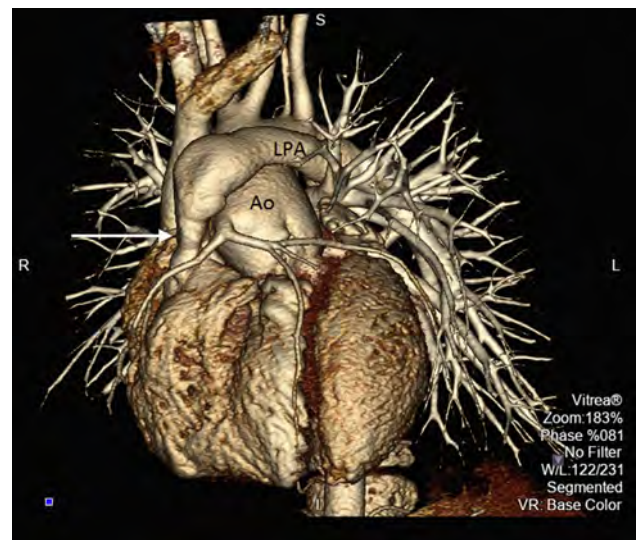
Three-dimensional reconstruction of computed tomographic images from a patient with a conduit from the right ventricle to the pulmonary artery that is significantly obstructed (white arrow) after the Rastelli procedure. This image shows both the narrowed proximal conduit and the CA relationship to the conduit. Ao, Aorta; LPA, left pulmonary artery.
